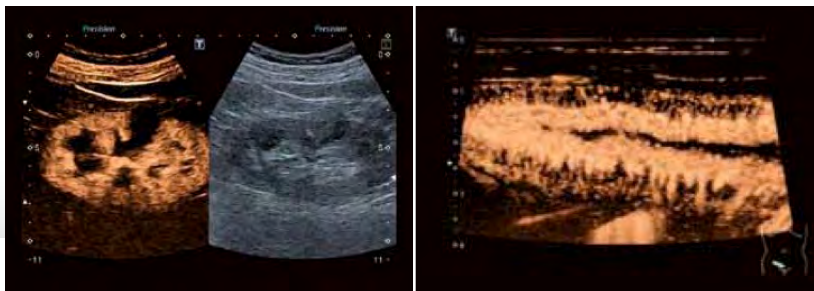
Kidney lesion and Crohn's disease: contrast-enhanced ultrasound leads to more depth and detail.
